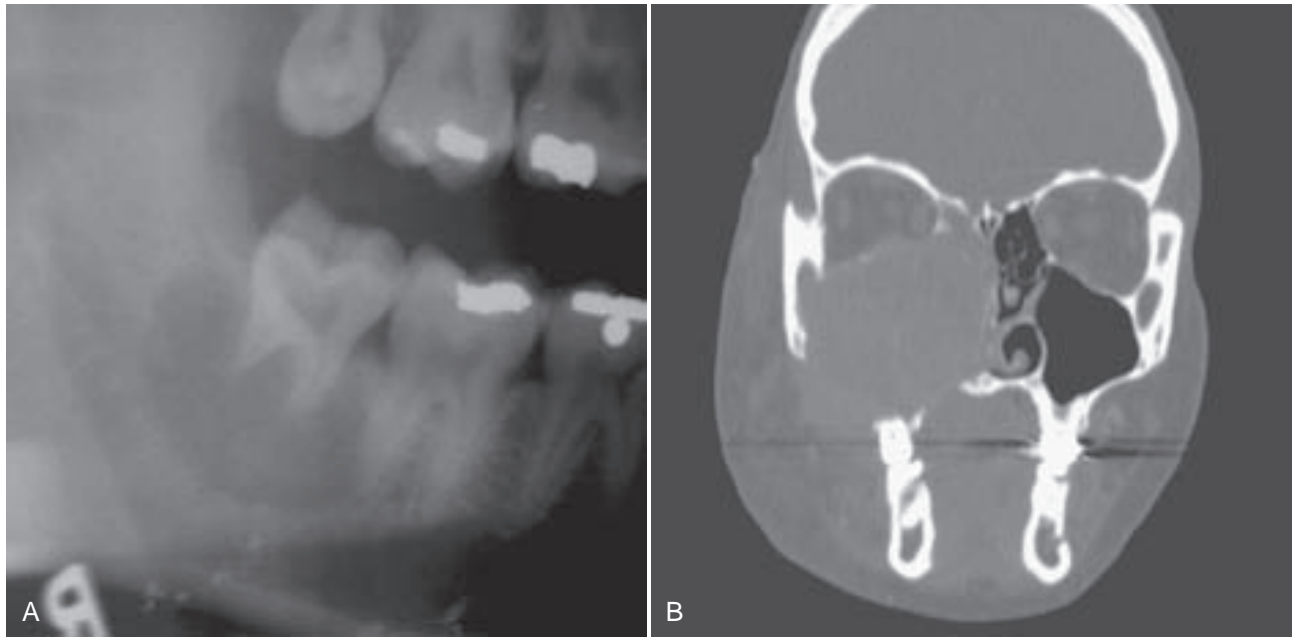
A, Nonaggressive central giant cell granuloma. Panoramic radiograph shows radiolucency at the apex of right mandibular second molar. B, Aggressive central giant cell granuloma. Recurrent tumor of right maxilla involving maxillary and ethmoid sinuses and nasal cavity. (A, Courtesy of Dr. Leonard B. Kaban and W. C. Guralnick, Harvard School of Dental Medicine and Massachusetts General Hospital, Boston, Mass; B, Courtesy of Dr. Leonard B. Kaban and Dr. Maria Troulis, Harvard School of Dental Medicine and Massachusetts General Hospital, Boston, Mass.)
